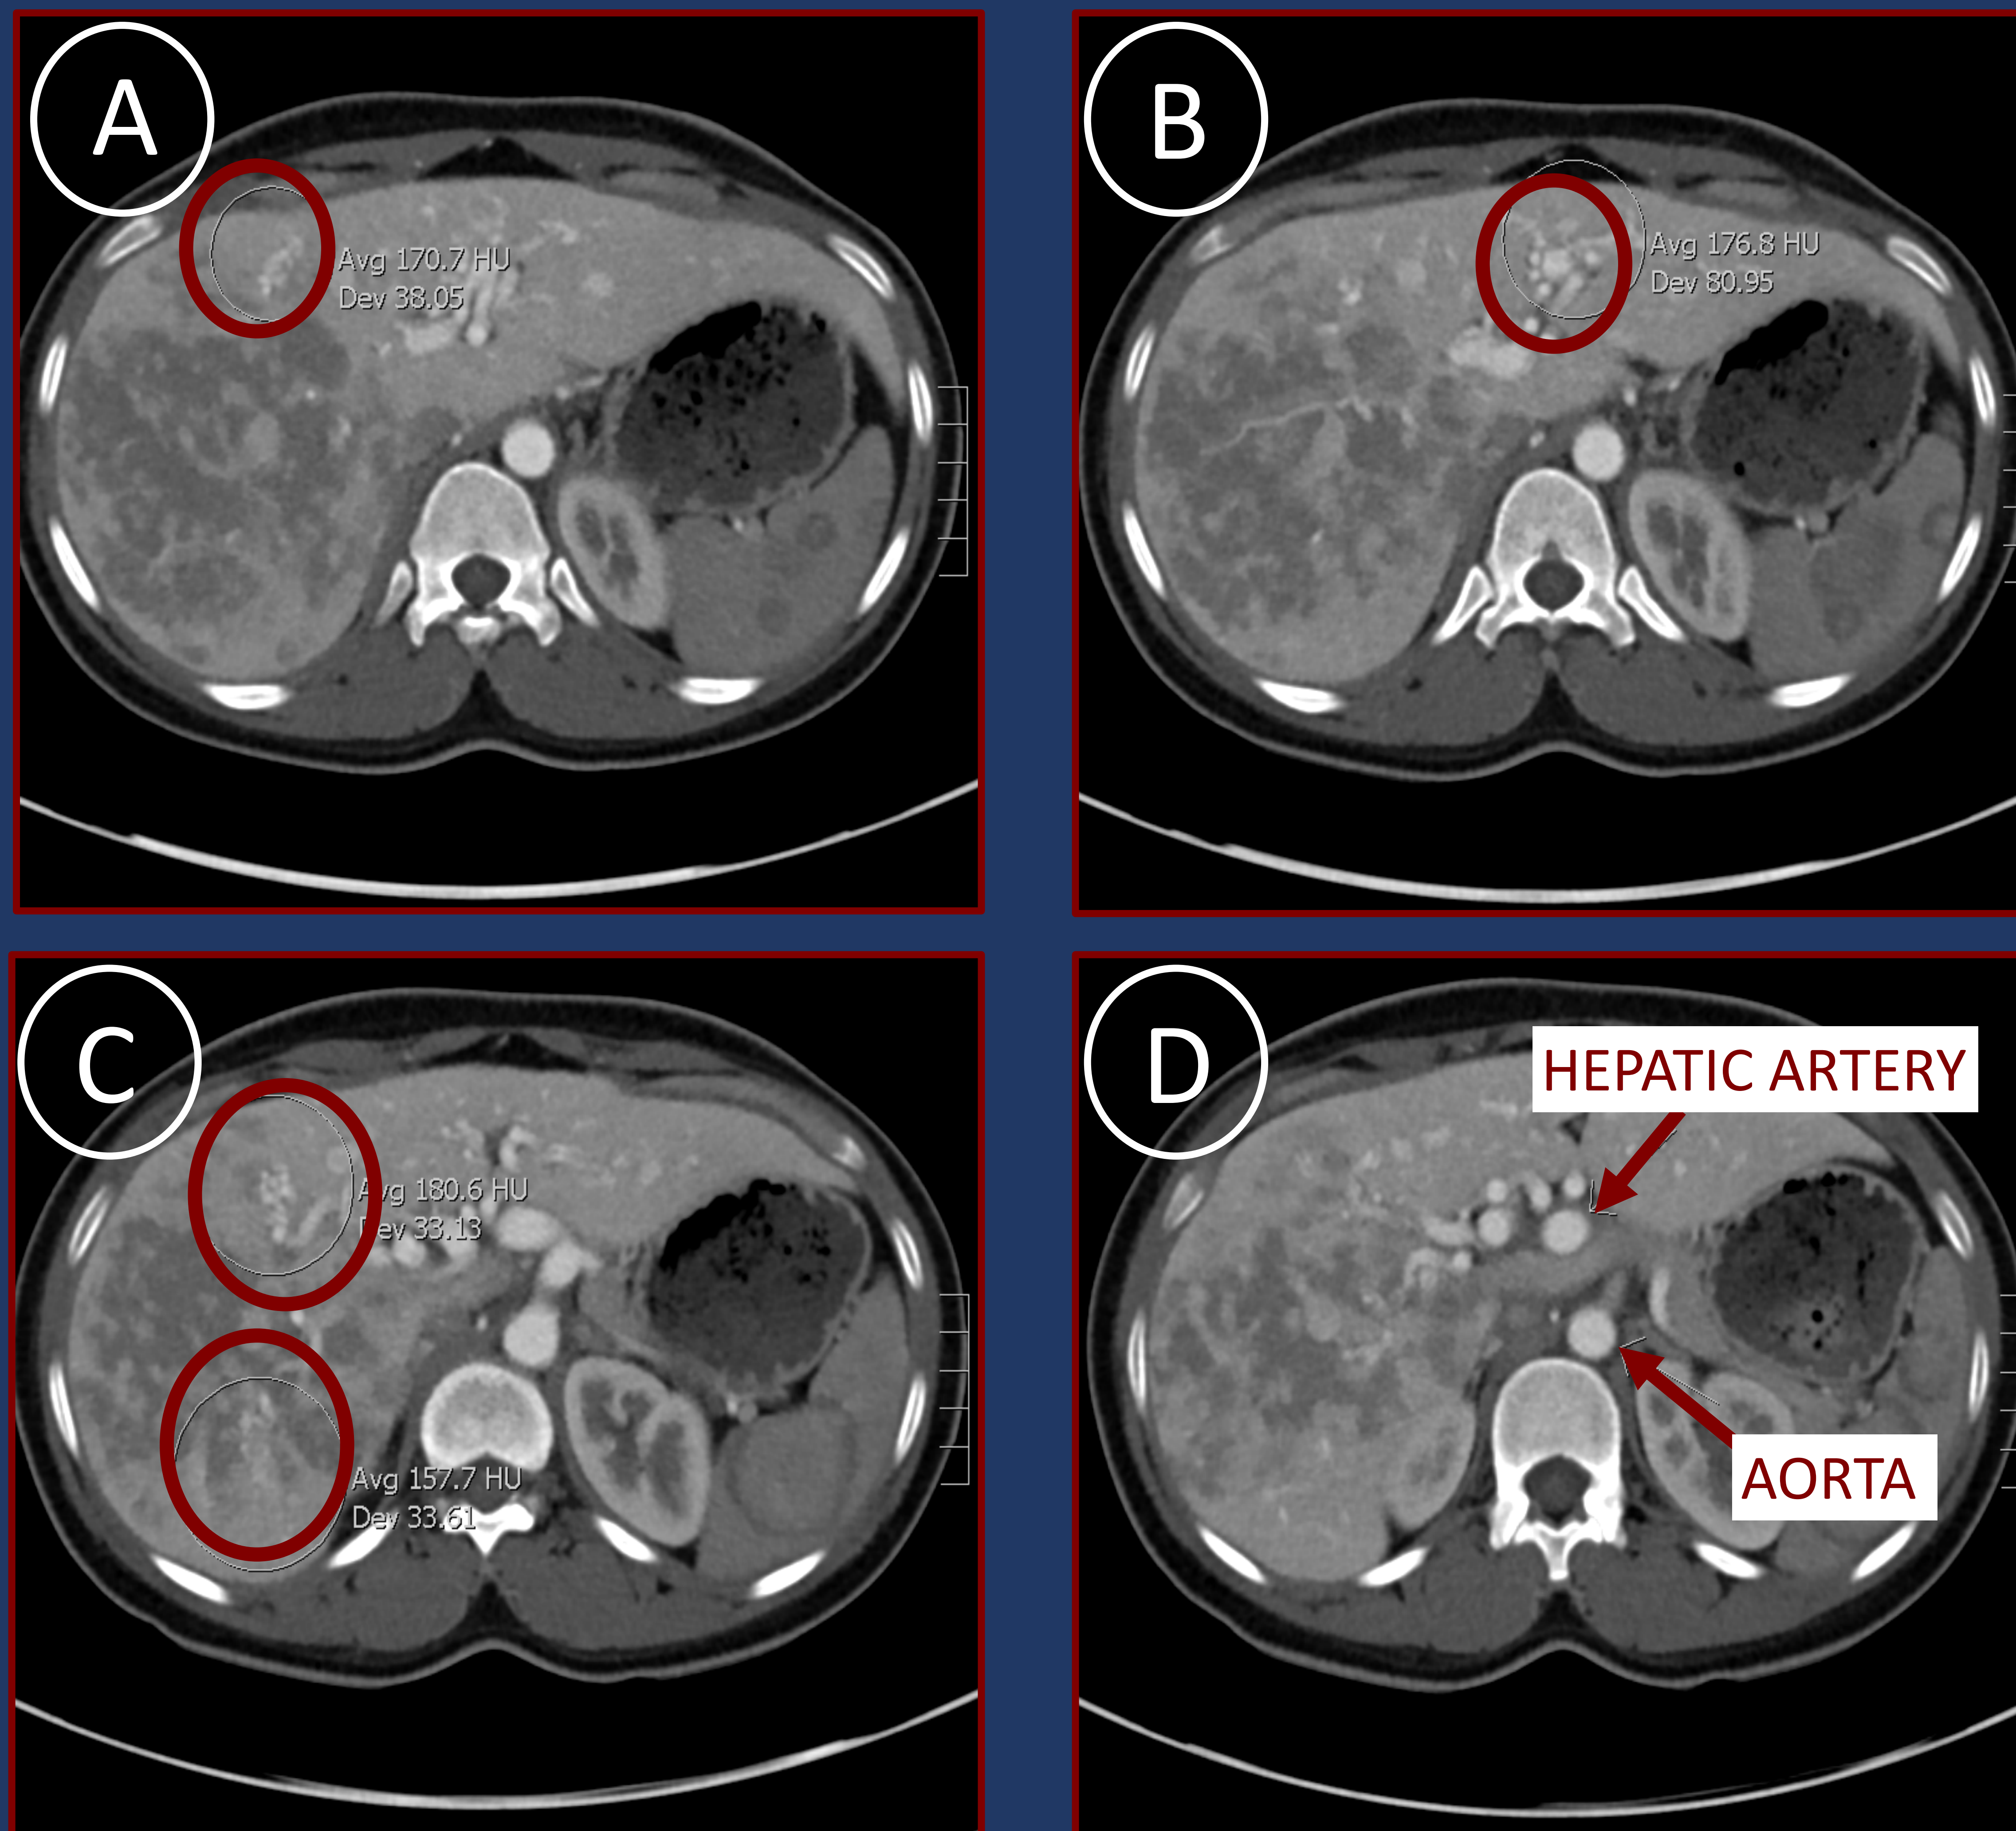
Three-phase liver CT obtained on second admission. Note four examples of hepatic AVM (circled, A-C). Significantly dilated hepatic a. when compared to aorta (D). Numerous other additional findings for discussion (e.g. delayed enhancement of hepatic parenchyma).
